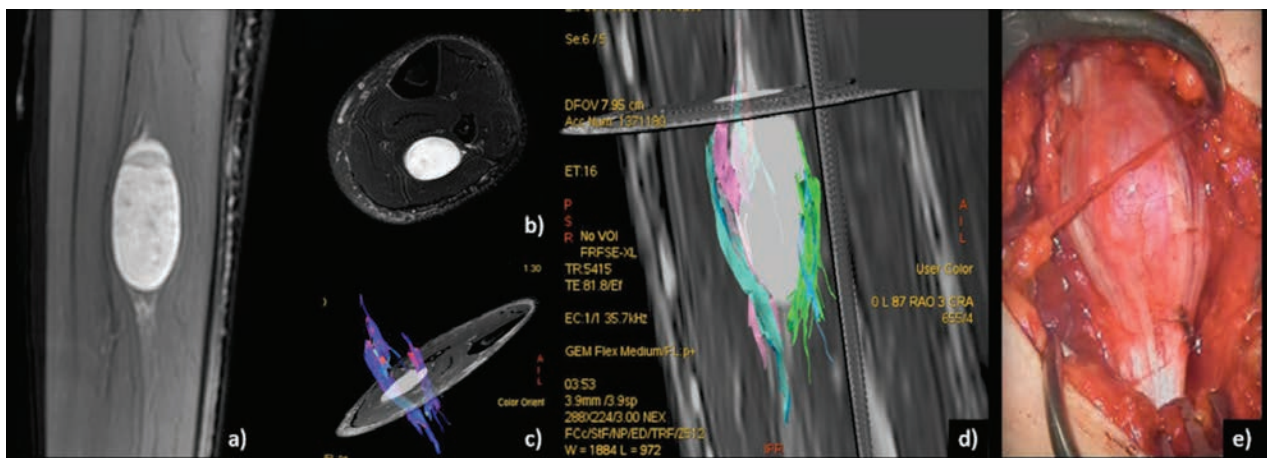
Post-contrast MR images (a, b) of an enhancing, fusiform lesion located at the lower third of the leg within flexor muscles. Tractography reconstructions (c, d) clearly depict in a 3D manner the relationship of the healthy nerve bundles splitted apart and arranged at the periphery of the lesion. Surgical finding (e)
